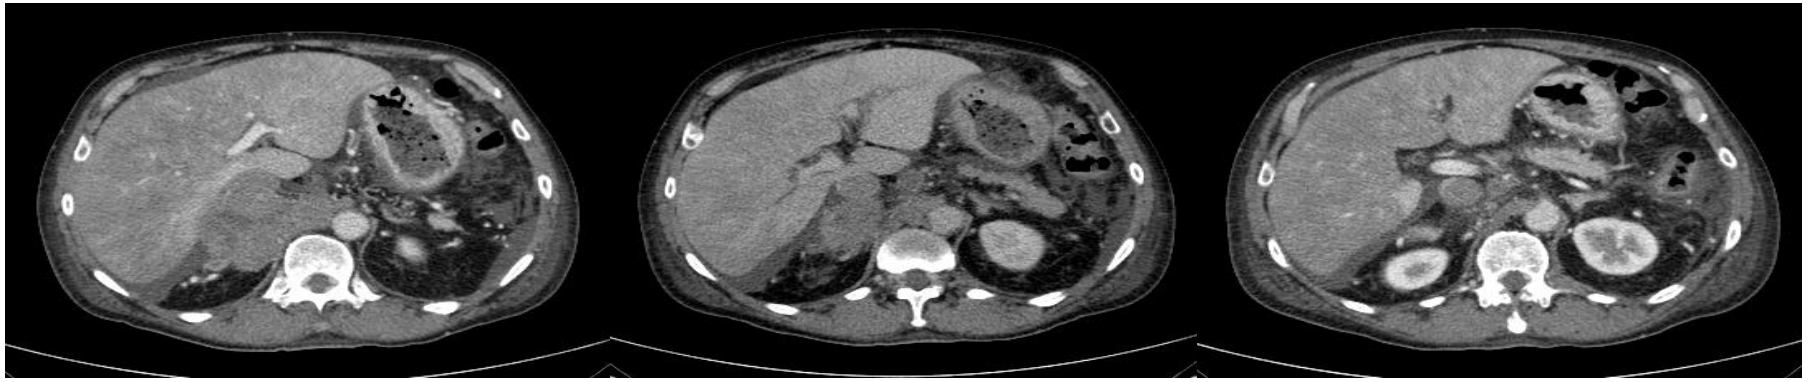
74 year old male with dyspnea and pulmonary nodules in chest radiograph. Body CT showed a voluminous mass in the right adrenal fossa, with liver and IVC infiltration. Autopsy confirmed adrenal carcinoma.
